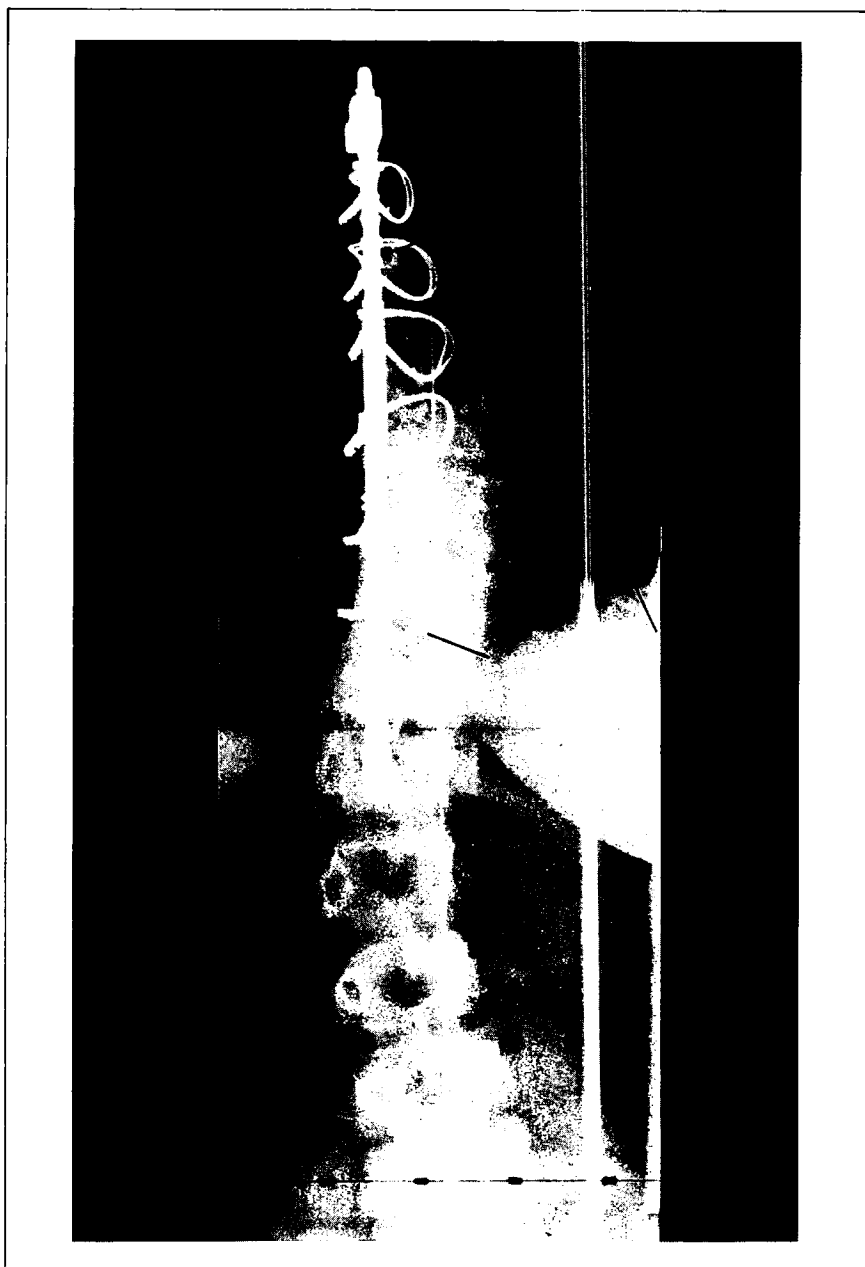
Antero-posterior radiograph of Harrington wires
